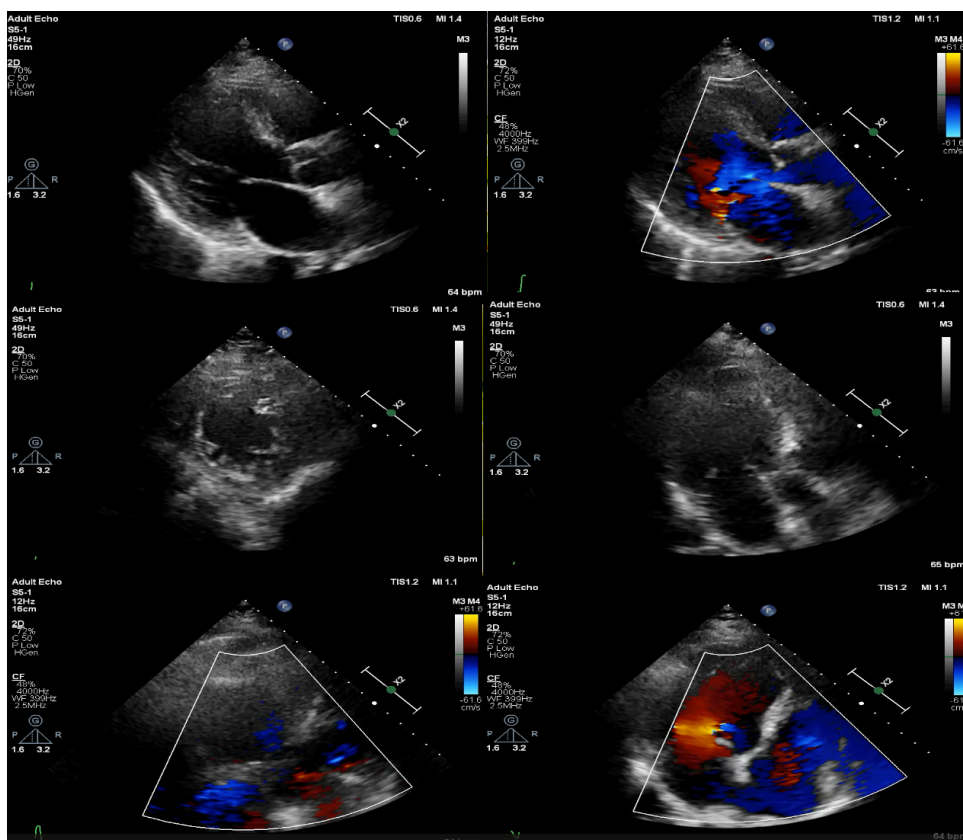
Transthoracic echocardiography performed at hospital admission.
